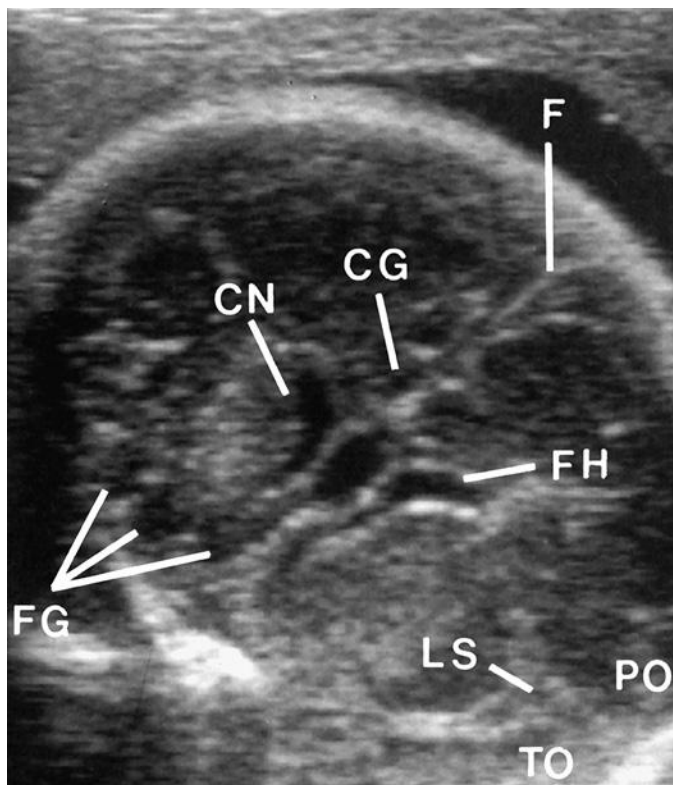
Coronal sonogram, anterior. CG, cingulate gyrus; CN, caudate nucleus; F, falx; FG, frontal gyri; FH, frontal horn; LS, lateral sulcus; PO, parietal operculum; TO, temporal operculum.
